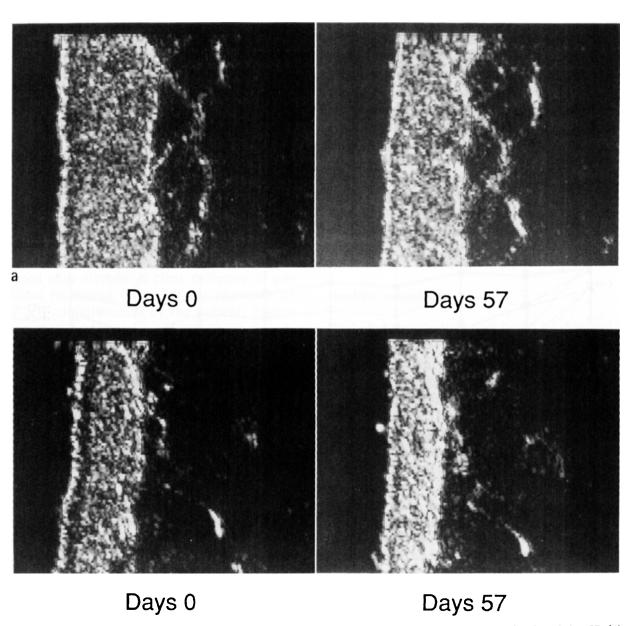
Skin thickness measurement by ultrasound imaging. Decreased skin thickness between day 0 and day 57: (a) BMV cream; (b) BMV fatty ointment; (c) MPA cream.
